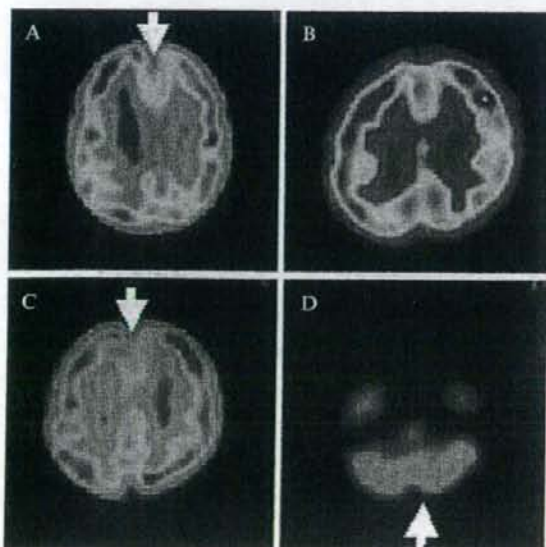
Single-photon emission computed tomography: axial sections of the brain show hypoperfusion of the frontal lobes. Arrows indicate the regions with abnormal intensity or perfusion. A, Case 1; B, case 2; C and D, case 3.
